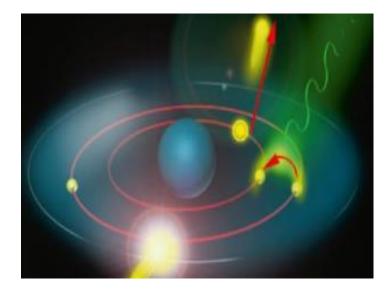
Characteristic of X-ray generation [9]
